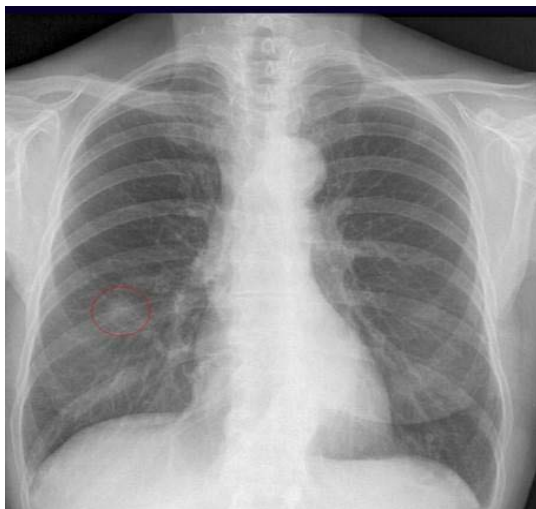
Initial chest x-ray showing diffuse consolidation (red ring).
